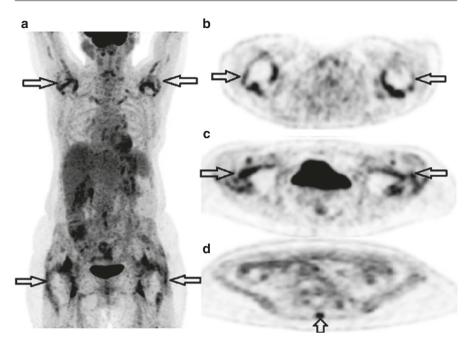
PET scan images in a patient with polymyalgia rheumatica. (a) Scan showed an increased FDG uptake around the shoulders and hips. (b) Transversal image of the shoulders. (c) Transversal image of the hips. (d) Increased FDG uptake in the spinous process of the lumbar vertebrae (in the transversal plane)
